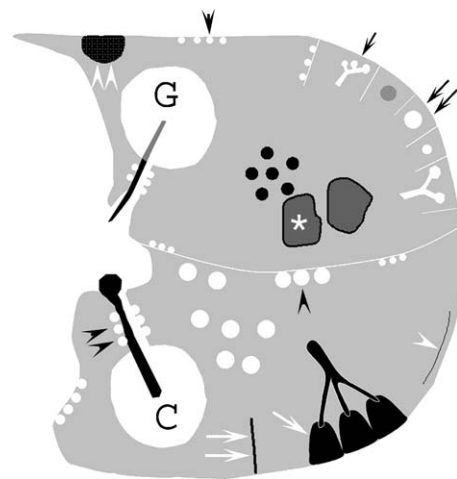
HRCT findings in patients with diffuse lung disease. Centrilobular nodules with (small black arrow) and without (double small black arrows) tree-in-bud; perilymphatic nodules (black arrowhead); peribronchovascular nodules (double black arrowheads); ground-glass opacity (G); consolidation (C); lobular low attenuation representing mosaic perfusion (white arrow); parenchymal bands (white double arrows); subpleural lines (white arrowhead); paraseptal (double white arrowheads) and centrilobular emphysema; and lung cysts (*).
